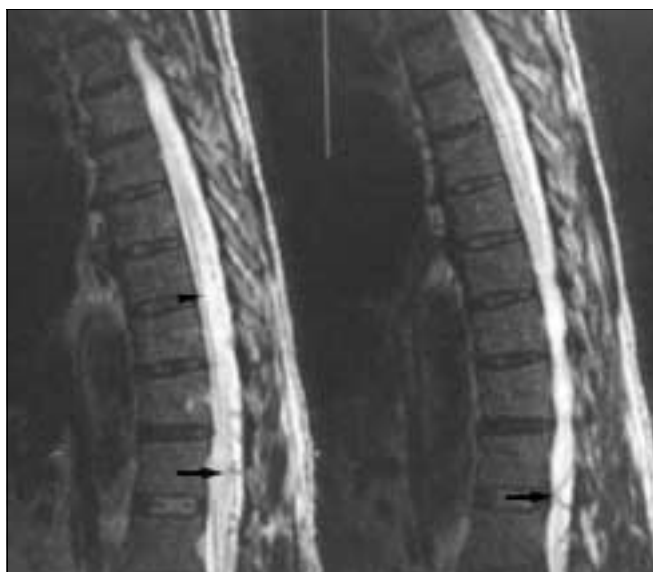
MRI of the thoracic spine, T2-weighted sagittal view showing high intensity of the thoracic spinal cord (arrowhead), with multiple flow voids (arrows) that represent the abnormal blood vessels.
